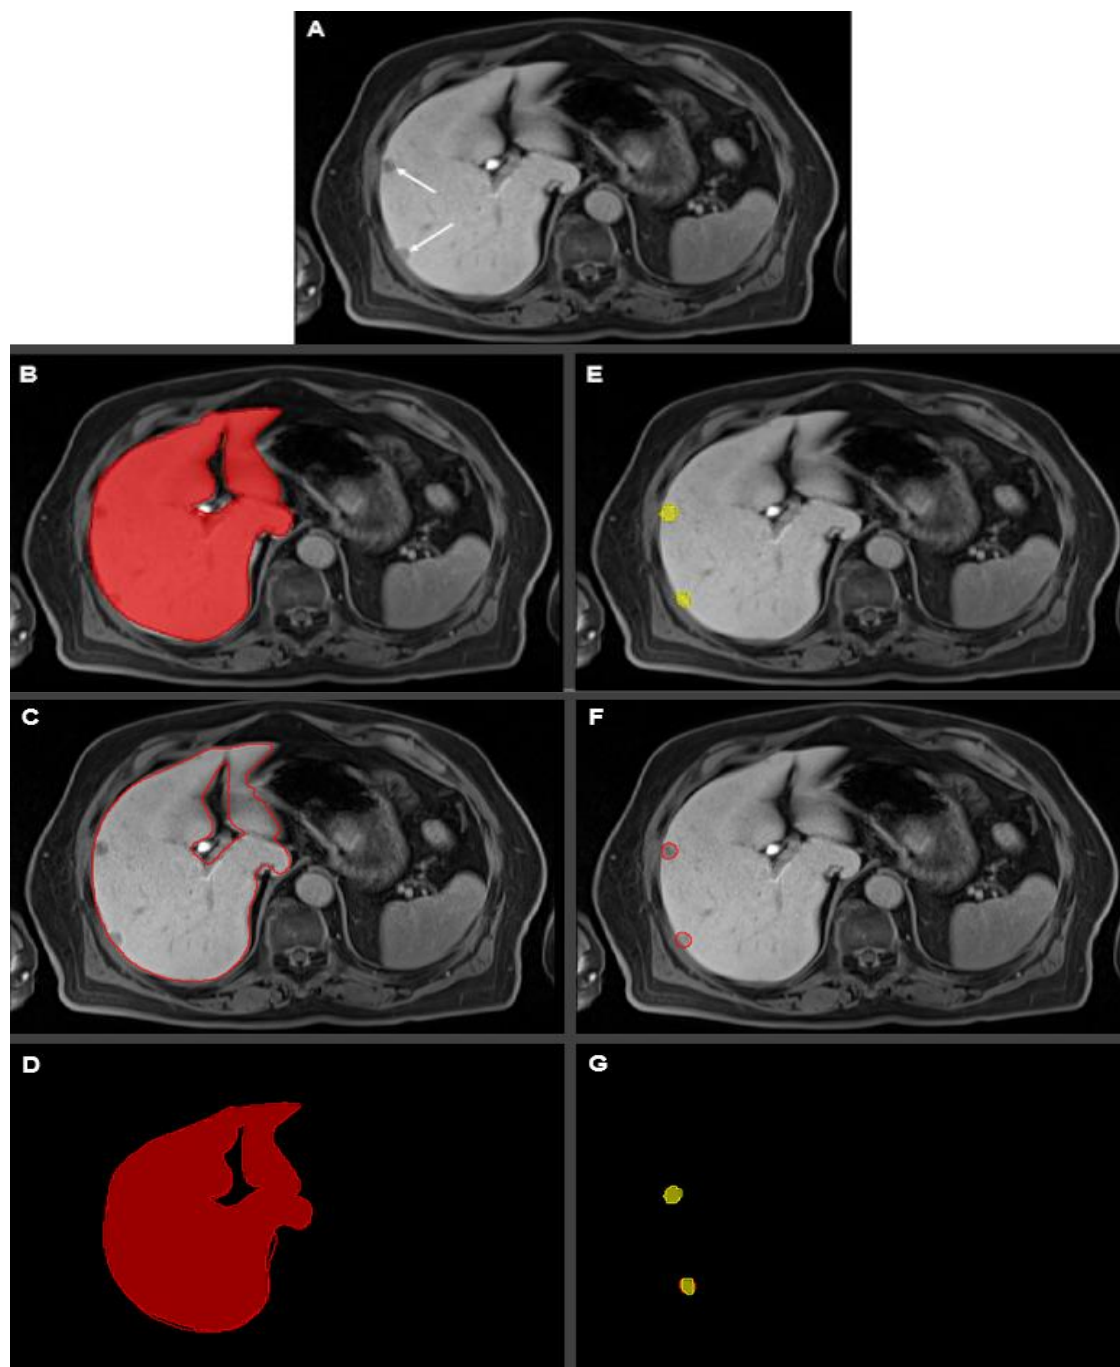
Comparison between manual and AI segmentations. (A) Original HBP MRI, the white arrows indicate the NELMs; (B, E) manual segmentation of the liver and NELMs; (C, F) AI's segmentation of the liver and NELMs; (D, G) overlapping the manually and AI's segmentation of the liver and NELMs.
